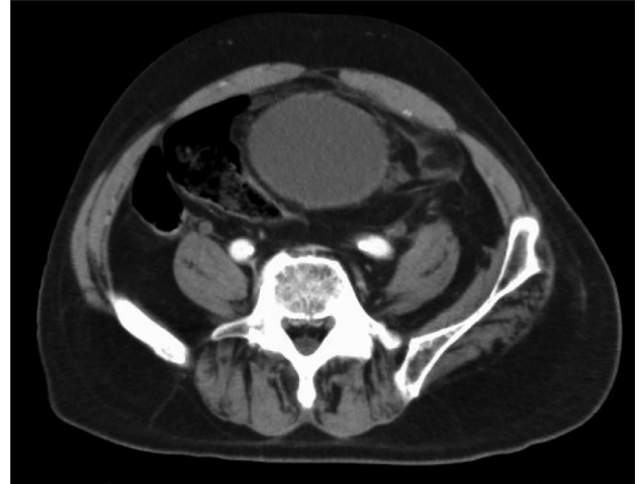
Single axial contrast-enhanced CT at the level of the urinary bladder demonstrates a dilated proximal sigmoid colon and zone of transition at the rectosigmoid junction between the urinary bladder and the sacrum. CT, computed tomography.
